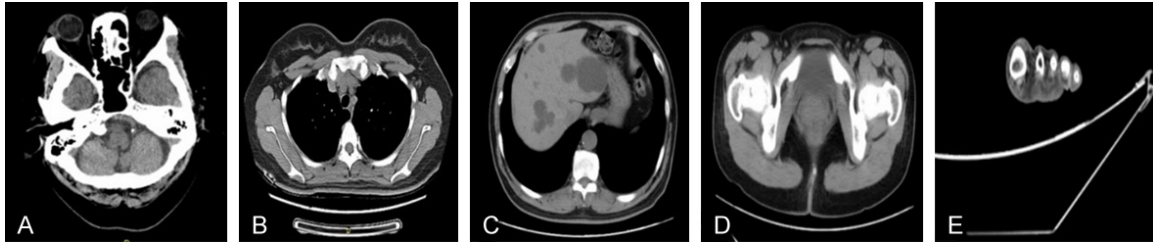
CT images of the five body parts. (A-E) represents the head, the chest, the abdomen, the pelvis, and the four limbs (a foot in the figure) respectively.
